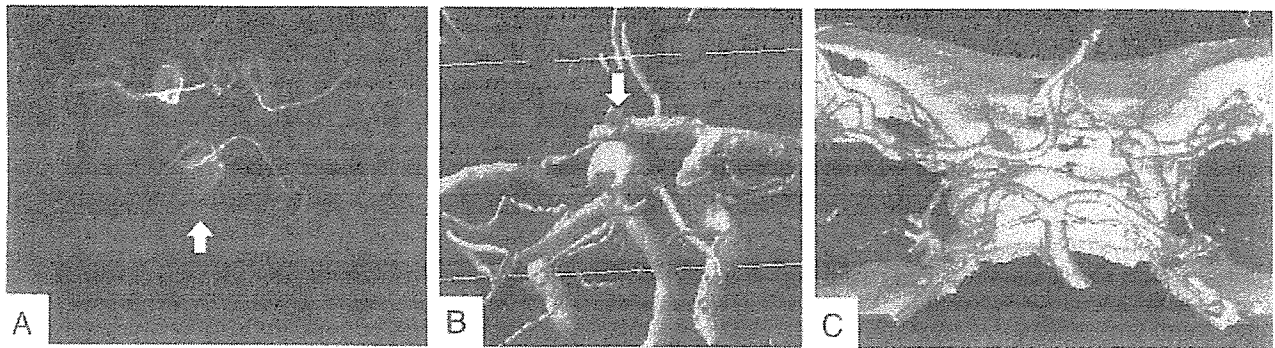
Examples of four vessels reconstructed from MRA image and CTA data.
